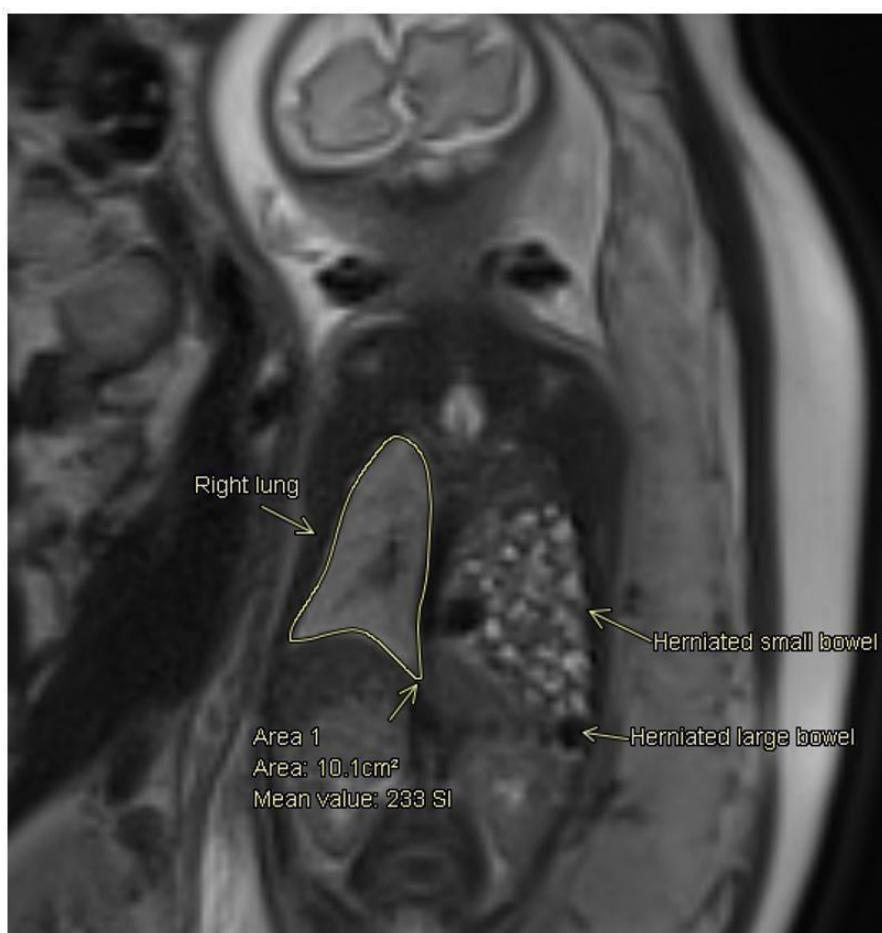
Coronal fetal MRI image of left-sided CDH with volume measurement of the right lung
